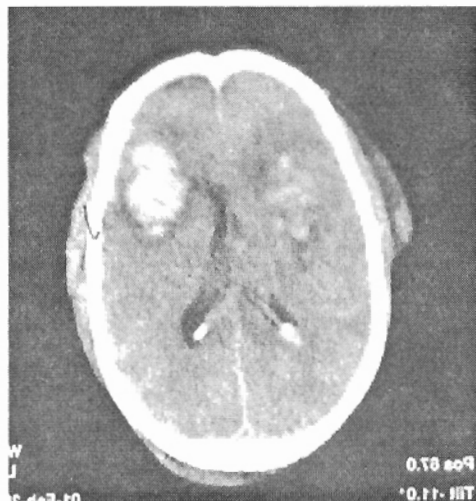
CT appearance of a right intracerebral haematoma with contre coup injury
